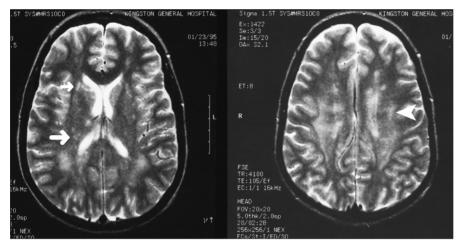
Axial T_c -weighted magnetic resonance images showing high intensity lesions in the periventricular deep white matter (arrowhead) and the thalamus (large arrow) and basal ganglia (small arrow).
